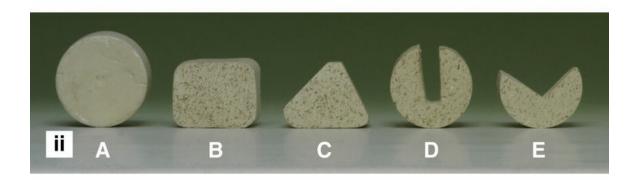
(i) Front view of four apparently similar cylinders made from plaster of Paris. (ii) The plan view shows the cylinders have varying internal designs and thicknesses. (iii) Radiographs of the apparently similar cylinders show how objects of similar shape and material, but of different densities, produce different radiographic images.
